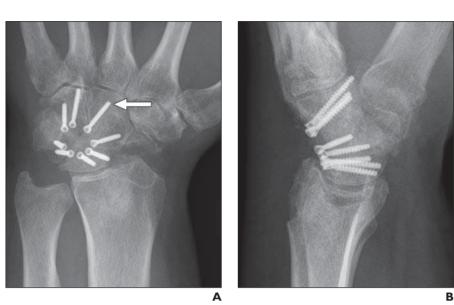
54-year-old man with 4-corner arthrodesis. A and B, Anteroposterior (A) and lateral (B) radiographs of wrist show eight screws (*arrow*, A) for midcarpal arthrodesis. Screws are fixated to carpal bones by radiolucent polyethylene plate (Xpode Fusion Plate, Stratmed).
